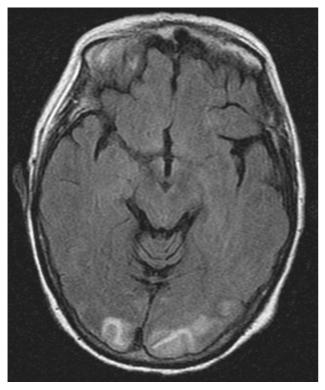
Magnetic resonance imaging scan of Patient 2. Fluid attenuated inversion recovery images at presentation showing increased signal in the occipital grey and white matter.
